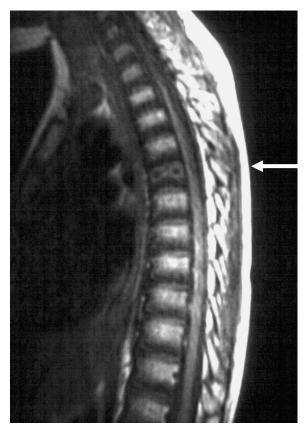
Spinal MRI at diagnosis (fifth thoracic vertebra).
